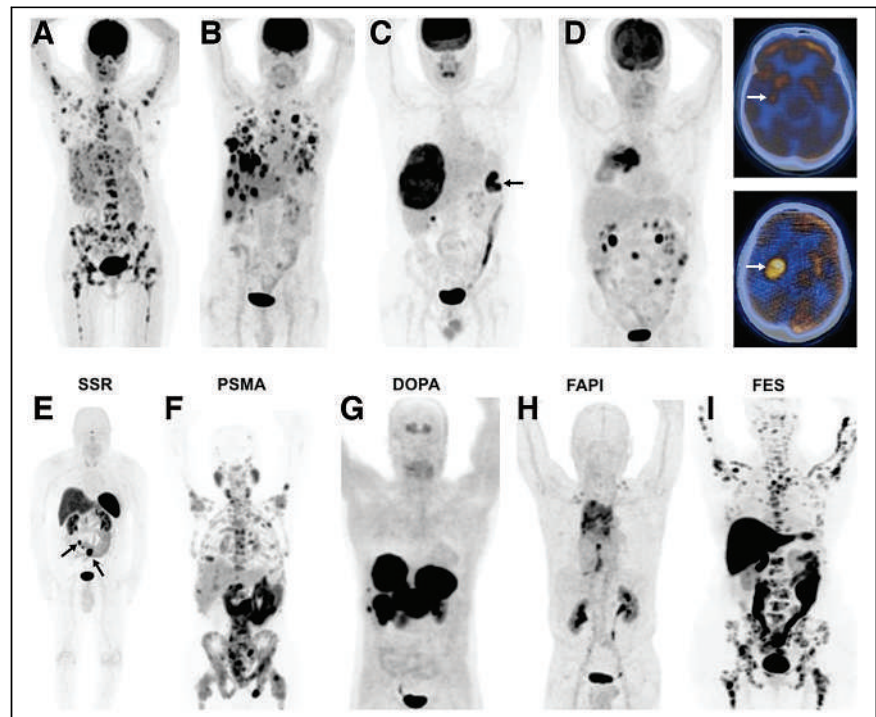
^{18}F -FDG PET images of various cancers and metastases (A–D), and PET images with various other radiotracers (E–I). (A) Right breast cancer (invasive ductal) with multiple metastases in bones, liver, right adrenal, and right axillary lymph nodes. (B) Right breast cancer (poorly differentiated neuroendocrine tumor) with multiple metastases in lungs, liver, and right axillary lymph nodes. (C) Colon cancer in splenic flexure (arrow), with large metastasis in liver. (D) Rapid progression of brain metastasis in patient with cancer in right lung. Whole-body image (left) demonstrated hypermetabolic right lung tumor. On initial PET/CT scan, there was mild focal uptake in tail of right putamen (top right, arrow), but 3 mo later (no treatment), significant increase in size and metabolic activity of metastatic focus in brain was seen (bottom right, arrow). (E) ^{68}Ga -DOTANOC PET image of patient with small-bowel carcinoid, showing primary tumor (left arrow) and multiple mesenteric metastases (right arrow), all with high somatostatin receptor binding. (F) ^{68}Ga -PSMA-11 PET image of patient with prostate cancer, showing diffuse bone and multiple abdominal and pelvic lymph node metastases. (G) ^{68}Ga -fluoro-L-dopa PET image of patient with history of surgically treated well-differentiated ileal neuroendocrine tumor, showing intense uptake in multiple large hepatic metastases. (Adapted from (43).) (H) ^{68}Ga -FAPI PET image of patient with non-small cell lung carcinoma, showing intense uptake in primary tumor and metastatic foci in mediastinum and, bilaterally, in supraclavicular regions. (Adapted from (44).) (I) ^{18}F -fluoroestradiol PET image of patient with invasive lobular breast cancer, showing extensive bone and bone marrow involvement with high estrogen receptor binding. (Adapted from (45).)
